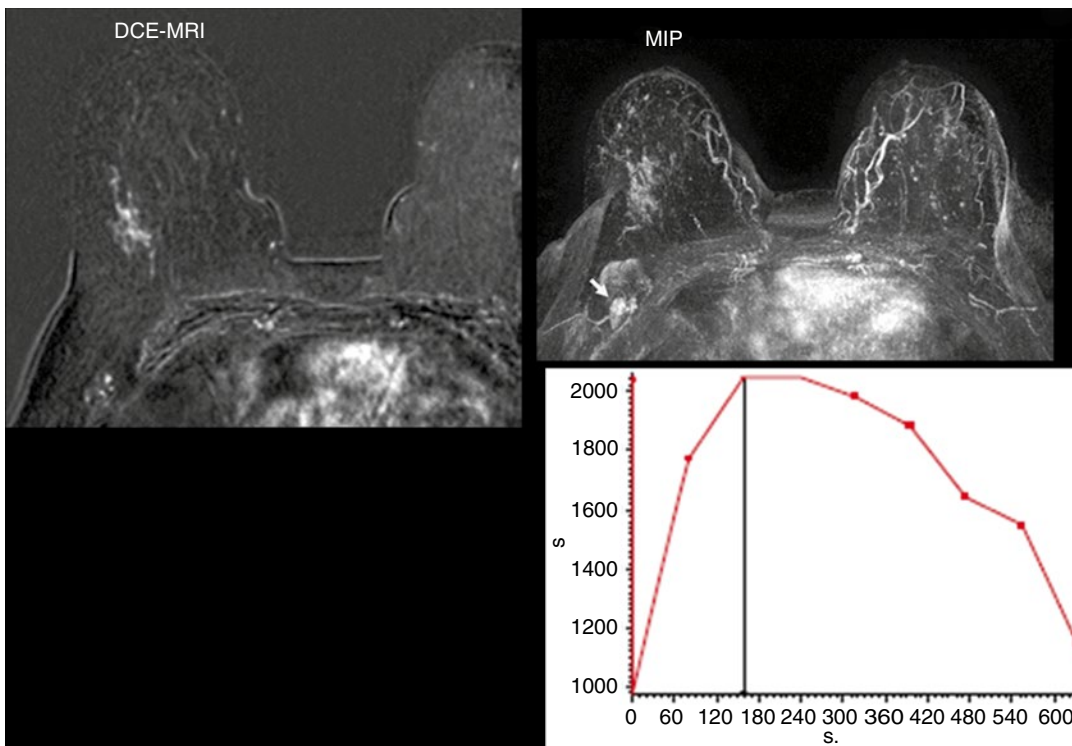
Infiltrating lobular carcinoma. DCE-MRI confirmed a regional enhancement with maximum diameter of 5 cm, whose enhancement pattern (type III TIC) was consistent with malignancy. Axial MIP of the first
